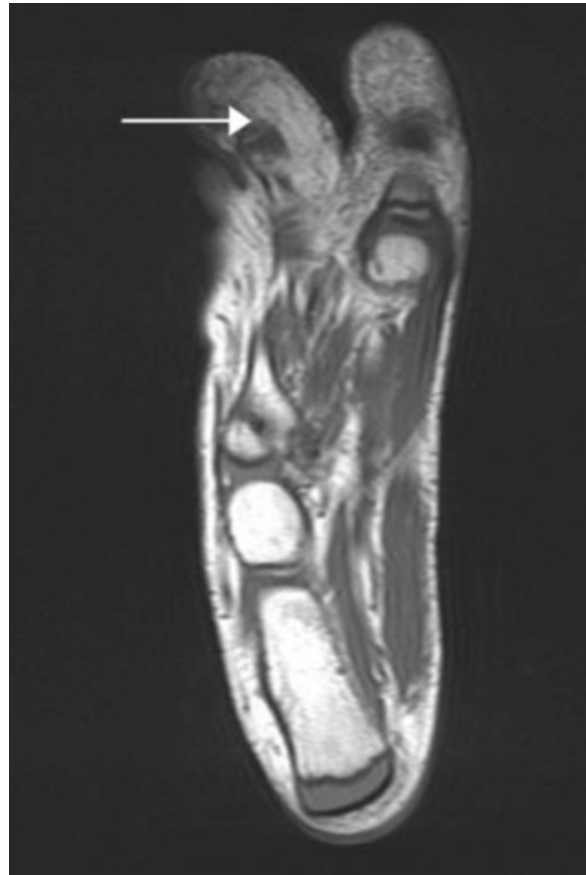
4-year-old boy with macrodystrophia lipomatosa. MRI axial T1 weighted image demonstrates increased adipose tissue (arrow) around the distal aspect of the second toe, which is laterally deviated.
